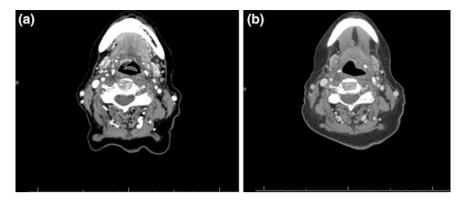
Computed tomography (CT) neck with contrast of small, superficial recurrent right base of tongue oropharyngeal squamous cell carcinoma (OPSCC) before (a) and after (b) transoral robotic surgery (TORS)
